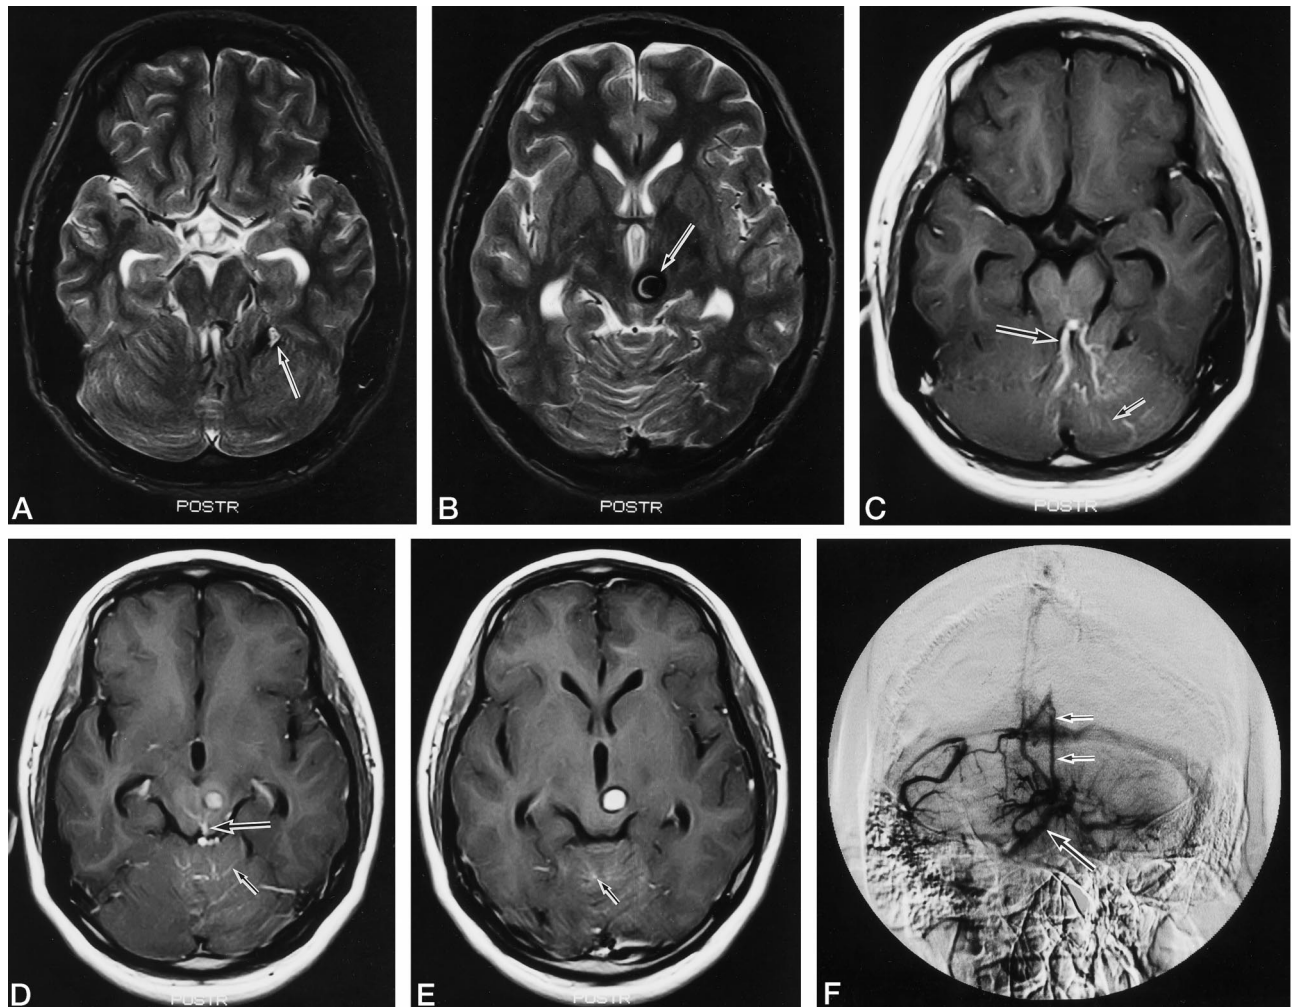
A and B, Axial T2-weighted images (4500/112/1) show OVMs in the left cerebellar hemisphere (arrow, A) and the midbrain (arrow, B). C–E, Contrast-enhanced T1-weighted images (550/15/2) show dilated medullary veins (small arrow) and collecting veins (large arrow) in the midbrain and both cerebellar hemispheres. F, Venous phase of left vertebral angiogram shows a paucity of cortical veins in the cerebellar hemisphere in addition to dilated medullary veins in the brain stem and both cerebellar hemispheres. One of the collecting veins is the contralateral lateral transpontine vein (large arrow), the other is the precentral cerebellar vein (small arrows).
